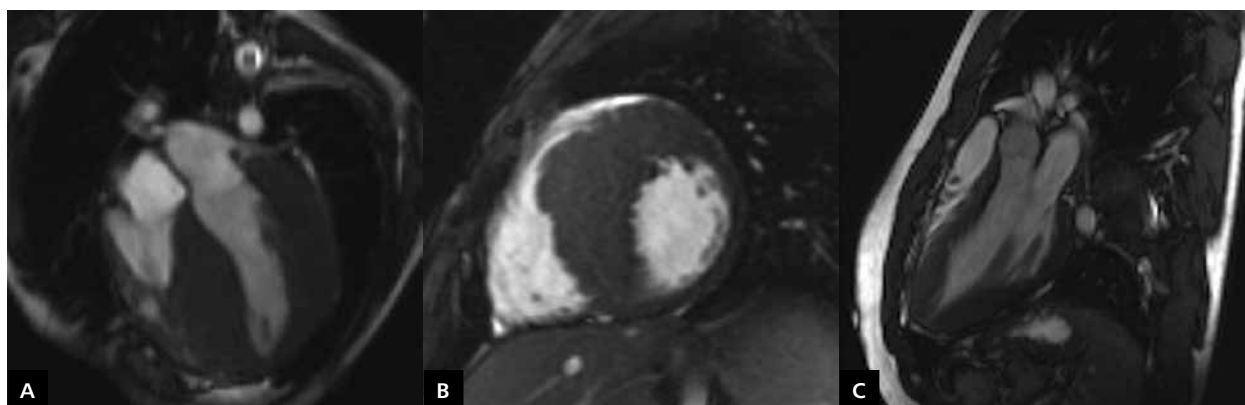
Cardiac magnetic resonance images in patients with hypertrophic cardiomyopathy; A. Four-chamber view, cine SSFP sequence. Massive hypertrophy of the interventricular septum and left ventricular lateral wall is seen; B. Short-axis view, cine SSFP sequence. Massive interventricular septum hypertrophy is seen; C. Three-chamber view in a patient with apical hypertrophic cardiomyopathy, cine SSFP sequence
